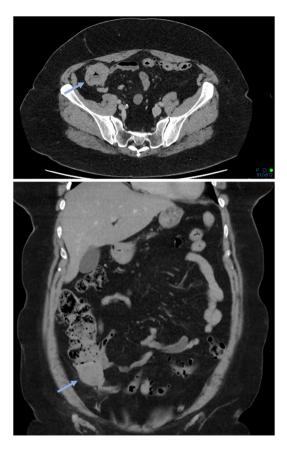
Initial CT (top—axial, bottom—coronal) demonstrating caecal thickening.
